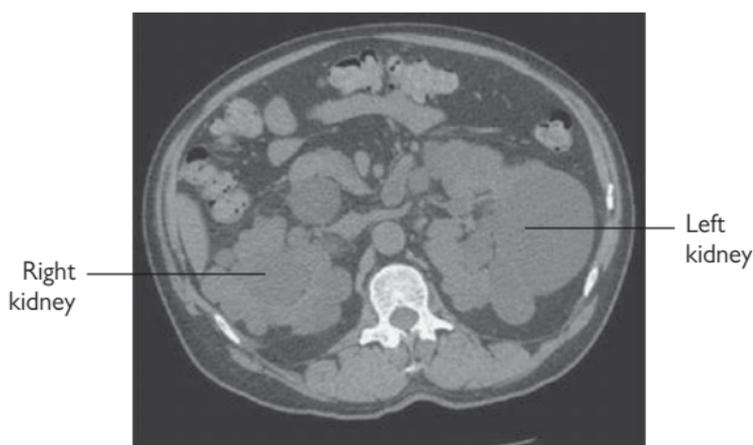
Axial section from a non-contrast CT scan demonstrating bilateral ADPKD.
